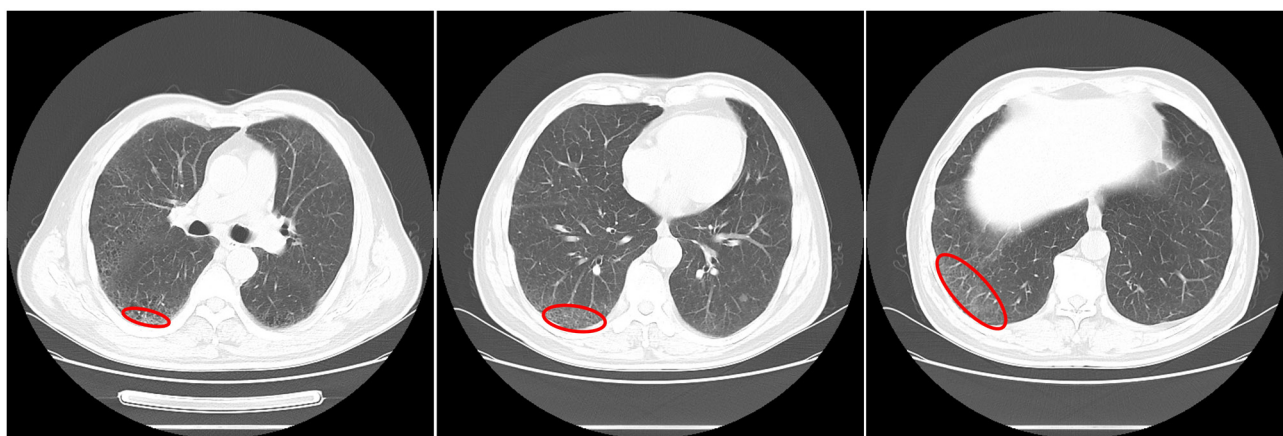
Chest CT in July 2019 indicating that the ground glass opacity was further absorbed and decreased (lesion sites are circled in red, 2019 July 30).
